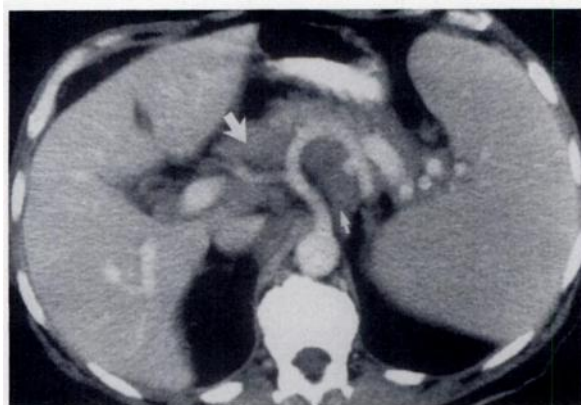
(15) CT scan of a patient with primary biliary cirrhosis reveals nonconfluent mild portal lymphadenopathy (arrows) surrounding the enhanced portal vein. (16) CT scan of a 57-year-old patient with lymphoma shows confluent portal lymphadenopathy (arrow). (17) CT scans of the liver in a patient with lymphoma reveals mild portal lymphadenopathy (arrow in a) resulting in periportal lymphedema (arrow in b).
